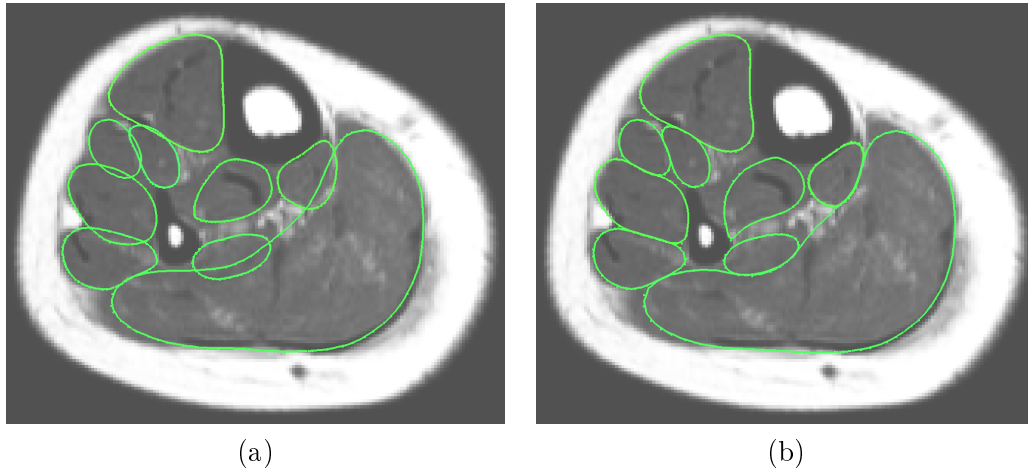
Axial view of a lower limb MR image showing muscle delineation (a) before and (b) after interpenetration removal.
